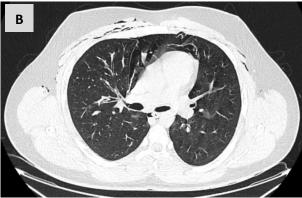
Chest computed tomography (CT) scan. It is observed in A: pneumomediastinum associated with subcutaneous emphysema, which compromises the anterior chest wall and dissects muscular planes. Centriacinar opacities with ground glass attenuation and septal thickening, predominantly in both upper lobes. B: Scarce continuous air in the minor fissure, which could be due to the Macklin Effect.
